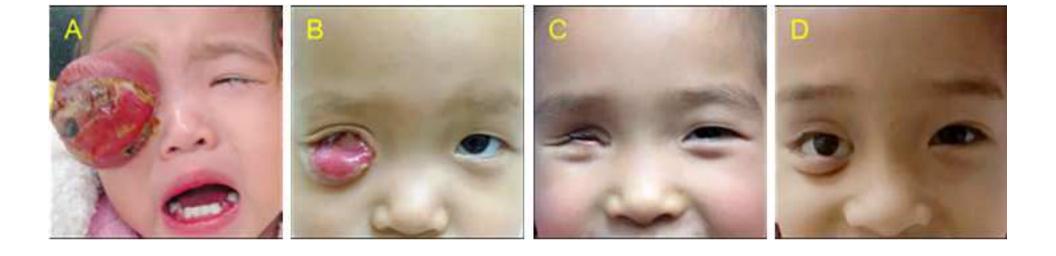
The appearance and CT performance of a patient before, after chemotherapy and after artificial eyes wearing
